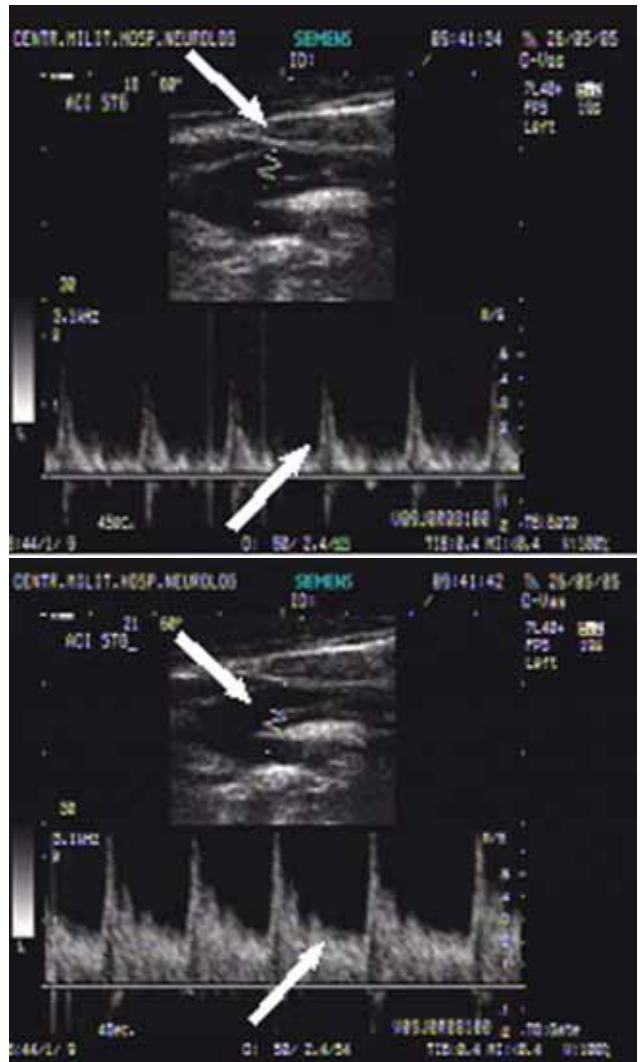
Echo – Doppler ultrasonography – sample gate positioned on one side and the other of the “septum” is showing different ultrasonography blood flow patterns – in the false lumen there is a non-specific blood flow pattern with decreased diastolic velocity, while in the main lumen there is a blood flow pattern very close to the normal.
